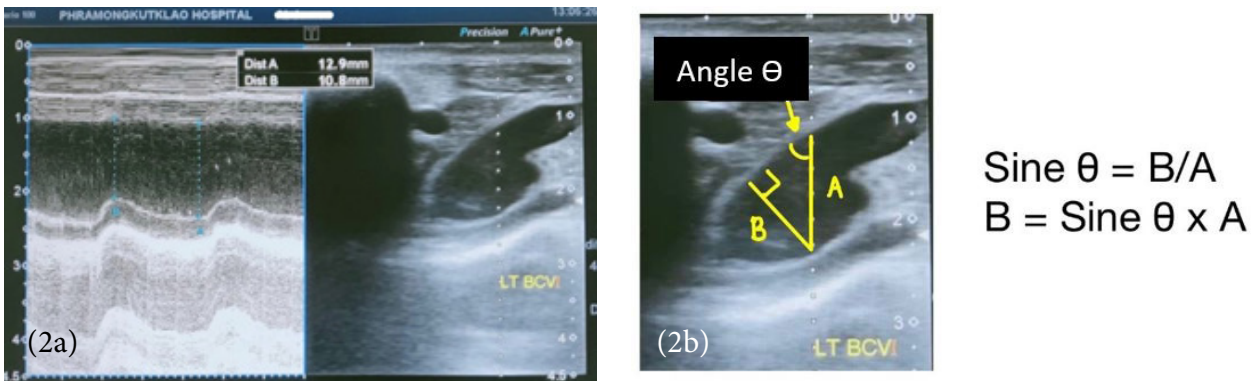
Ultrasonographic imaging of brachiocephalic vein in M-mode (2a) and calculation method of BVC diameter (2b).
